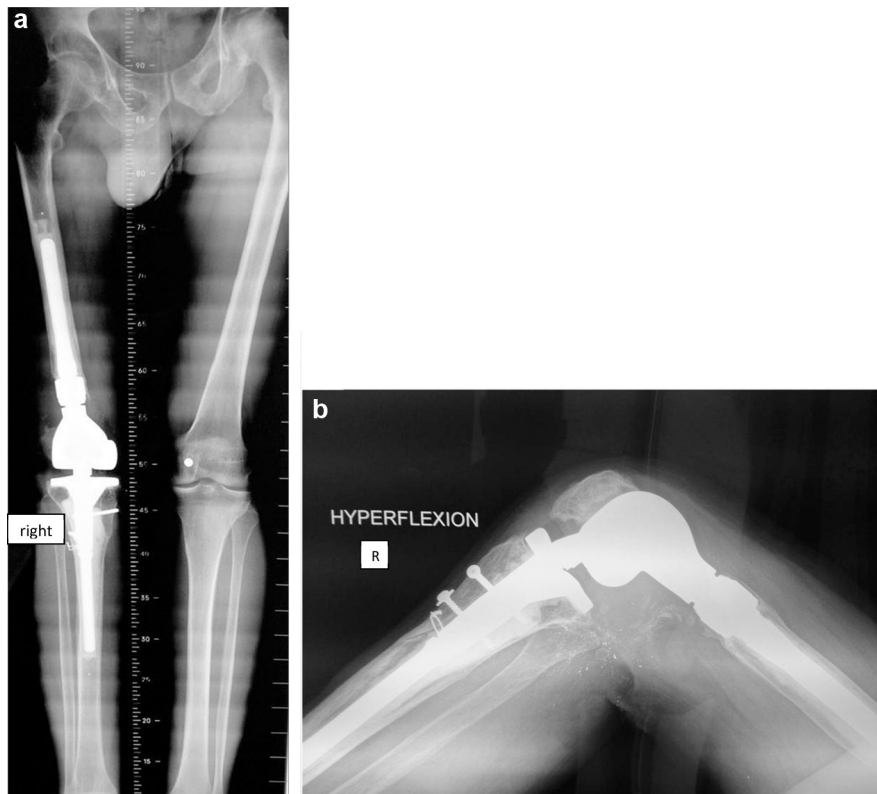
a, b: AP and lateral whole-knee X-ray in maximal flexion at 5-year follow-up.
